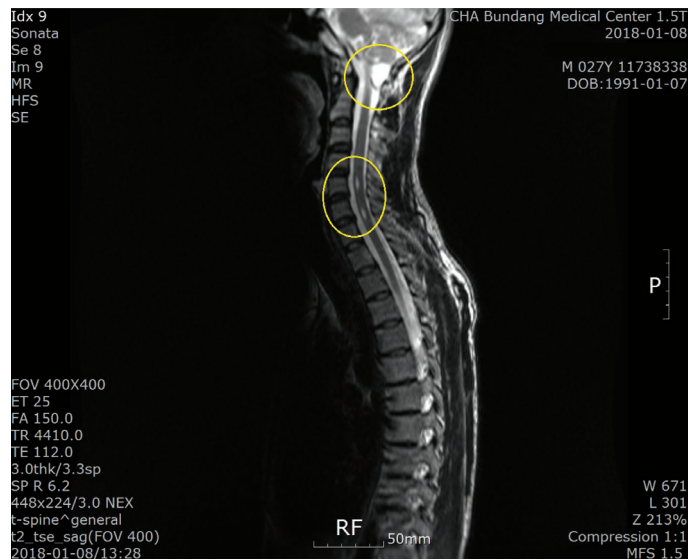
T2 weighted sagittal plane of magnetic resonance imaging (2018-01-08). The cavities in the spinal cord are shown (medulla oblongata, C5-6 level).
